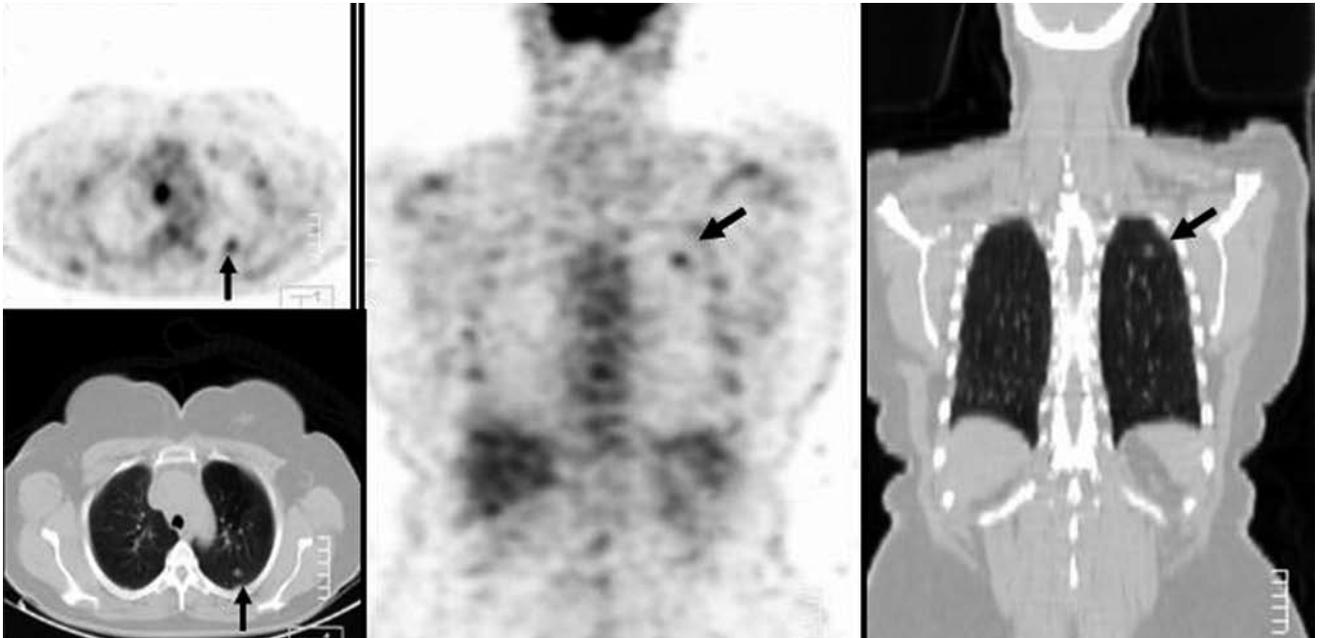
In a 38-year-old female patient with left breast cancer, a solitary pulmonary nodule was detected on FDG-PET and CT images in posterior upper localization of the left lung (black-arrow). Initially, the patient was thought to have developed metastasis as she had already a primary cancer; however, the final diagnosis was tuberculoma following partial lung resection.
